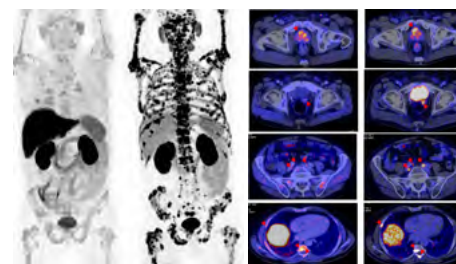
Comparison of MIP whole-body PET ^{11}C -choline (left) and ^{68}Ga -PSMA (right)
